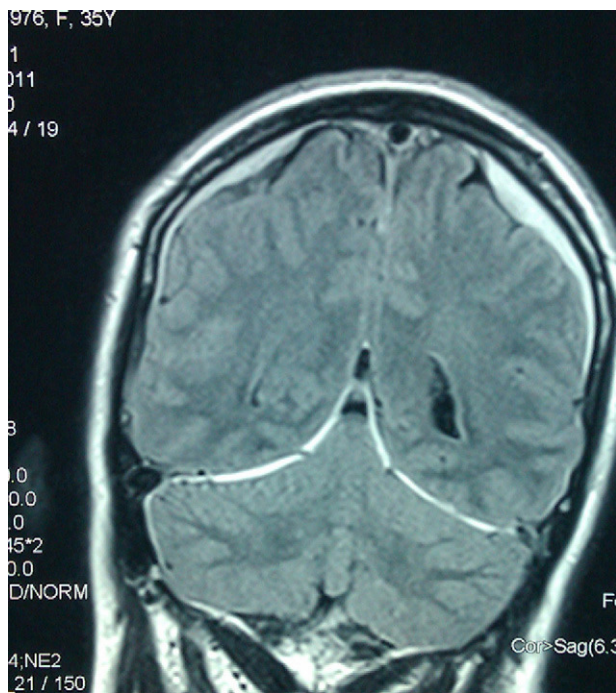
MRI FLAIR sequence. Bilateral subdural hygromas.
